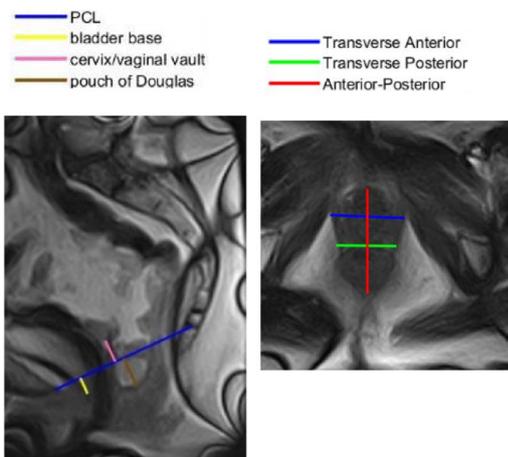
Sagittal (left) and transversal (right) MRI-scans of the pelvic floor
